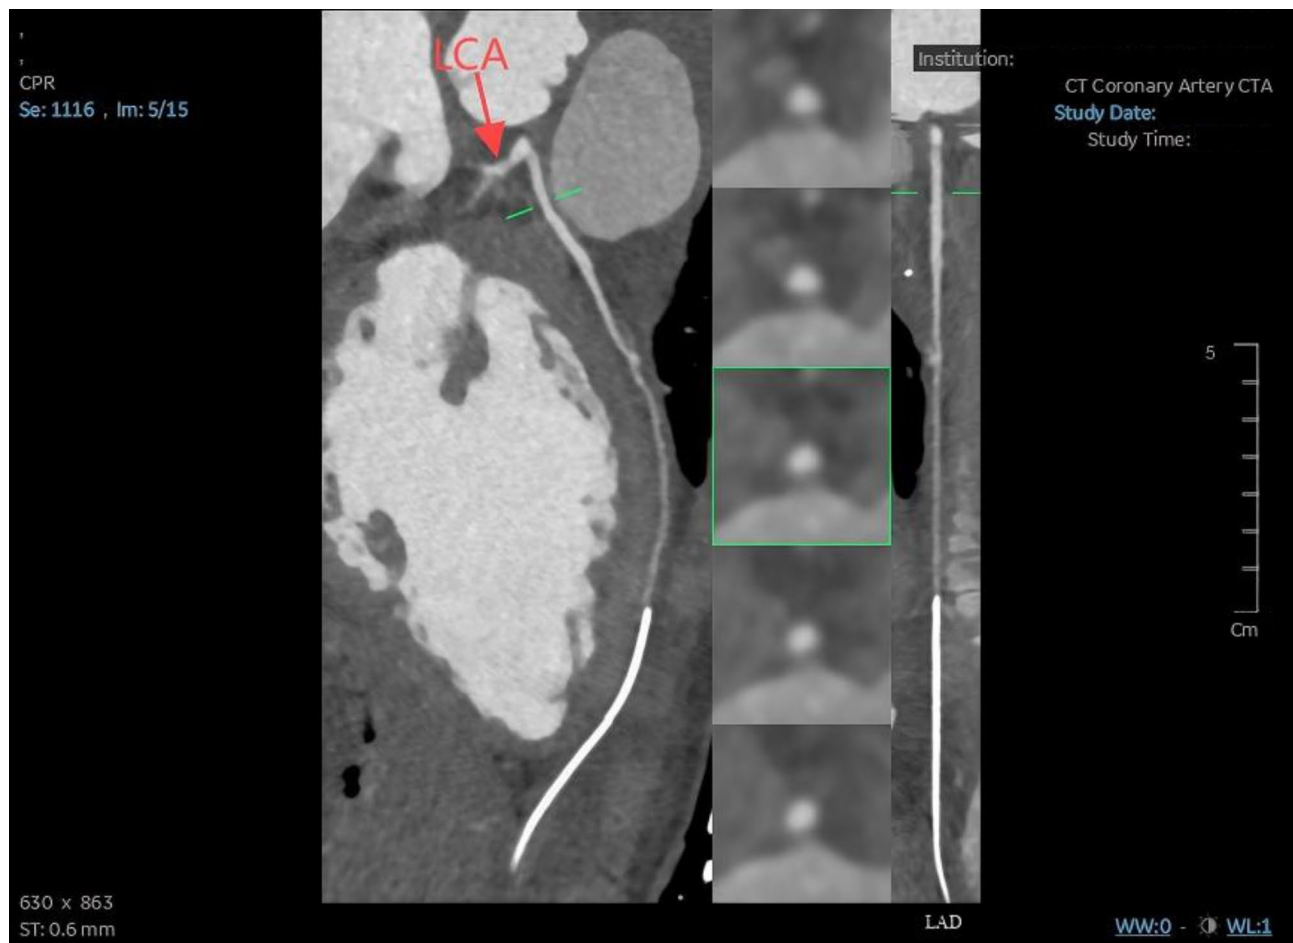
CTA results: (A) The right coronary artery is observed originating from the left coronary sinus of the aorta. (B) The left main coronary artery is not clearly visualized, while the left anterior descending branch is distinctly displayed
